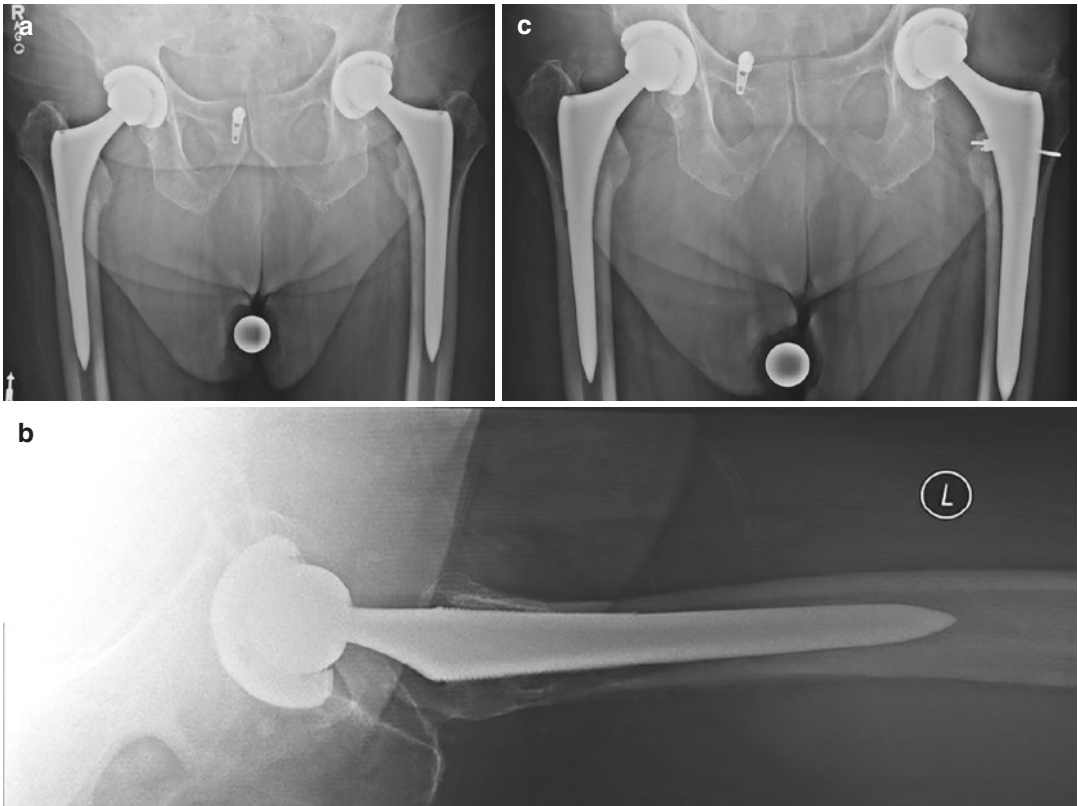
(a) Anteroposterior pelvis radiographs of a patient with a painful left hip arthroplasty with subtle radiographic signs of loosening of the femoral stem. (b) Cross-table lateral radiograph showing radiolucencies
